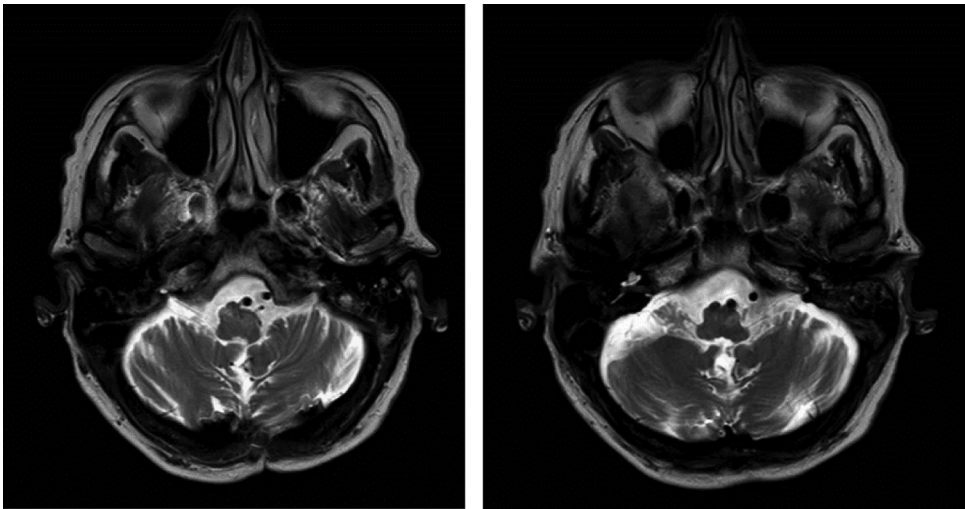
Patient 4: Postoperative last FUP T2-weighted brain MRI showing HOD with hyperintensity of both inferior olivary nuclei.
